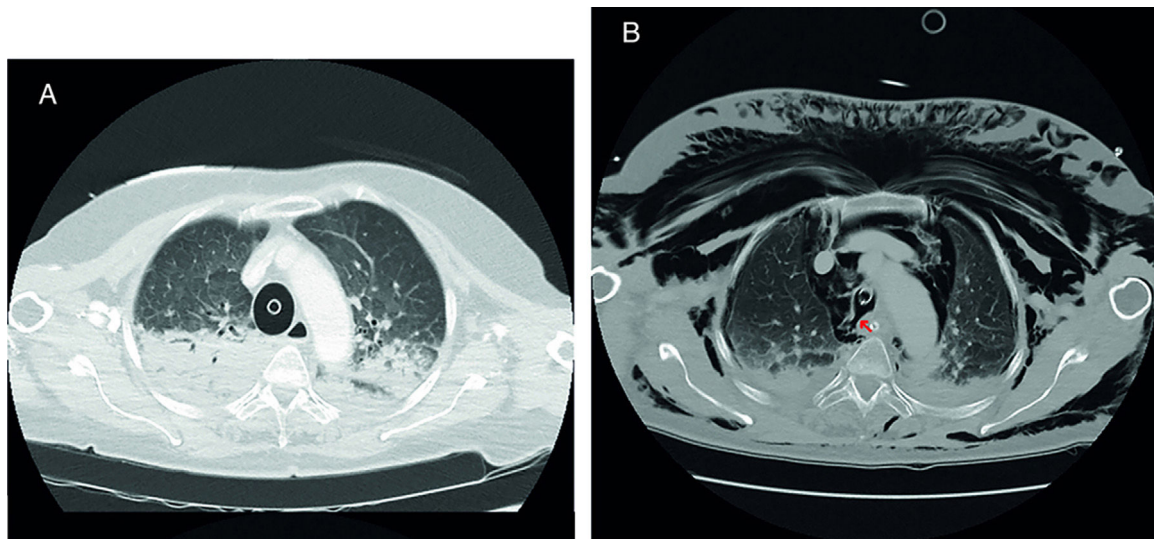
(A) Initial thoracic CT scan. (B) Thoracic CT scan at the ICU.
